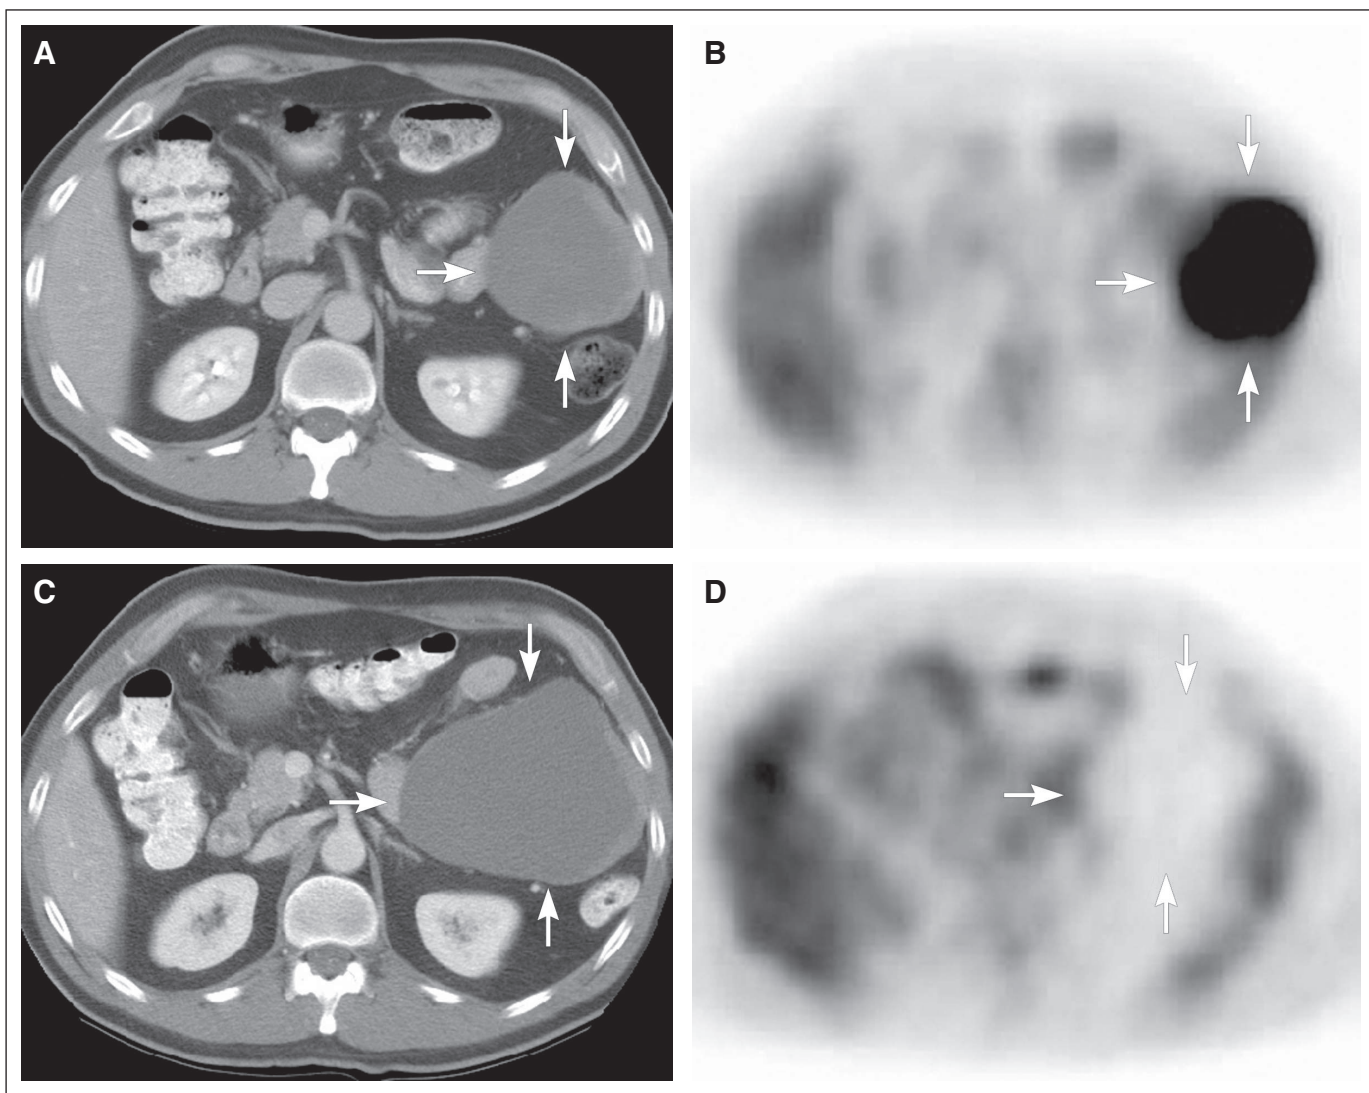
A 51-year-old male with primary gastrointestinal stromal tumors of colon and recurrent peritoneal metastases. Pretreatment computed tomography (CT) scan shows (A) a relatively low-density peritoneal mass (42 Hounsfield units [HU]) (→) corresponding to (B) a lesion with markedly increased glucose uptake (→) on positron emission tomography using [^{18}F]fluorodeoxyglucose (FDG-PET). At 2 months after treatment, (C) the mass (→) has become larger, however, the CT density has decreased (30 HU), (D) with no appreciable glucose uptake (→) on FDG-PET, corresponding to clinical improvement. (Reprinted with permission.¹¹)
